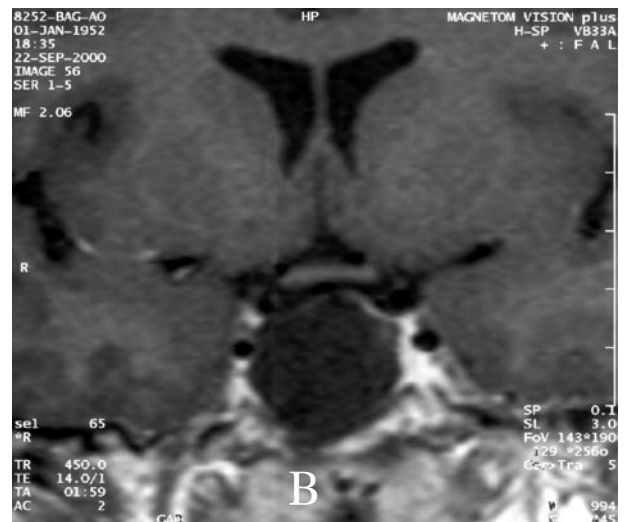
The lesion showed the same density as the surrounding subarachnoid space on contrast-enhanced T1-weighted magnetic resonans images (A-B).
